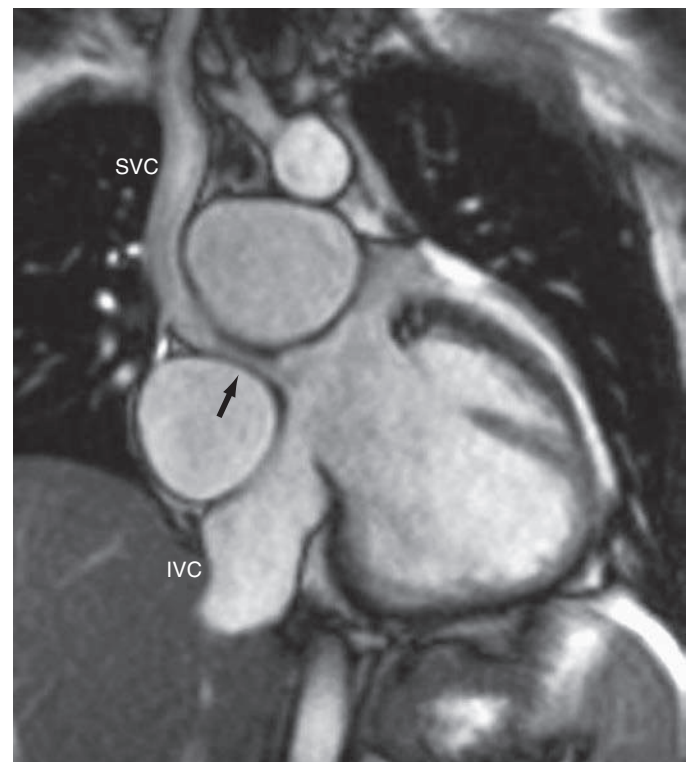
Magnetic resonance imaging scan of a patient after the Mustard operation showing the superior and inferior vena cava draining into the systemic venous baffle. The arrow indicates stenosis of the superior limb of the systemic venous baffle.
